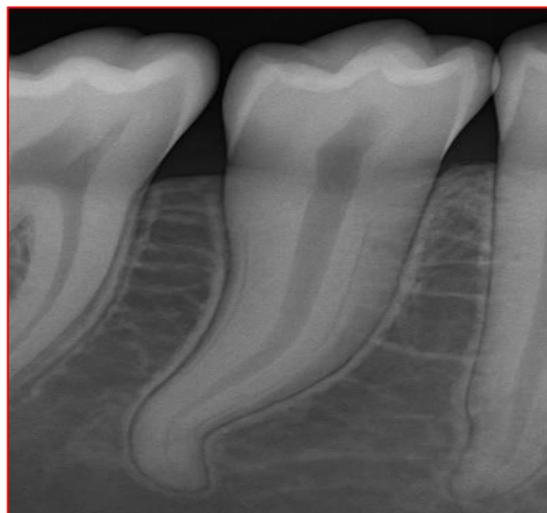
Periapical image showing a mandibular premolar with dilacerated root.
